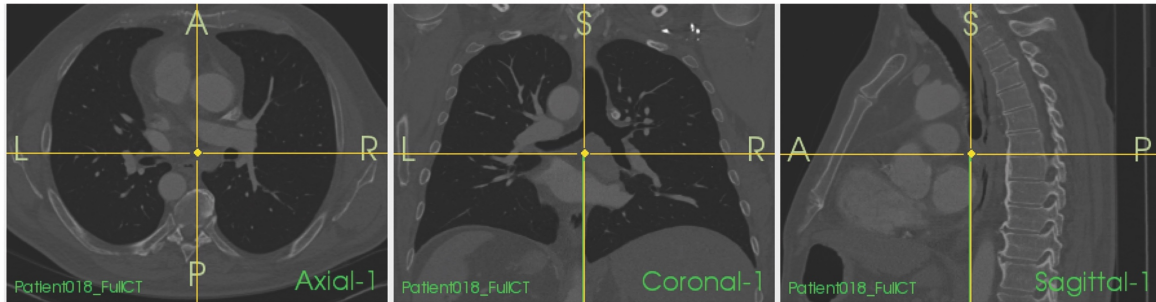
ACS: Axial, coronal and sagittal views of CT data.
